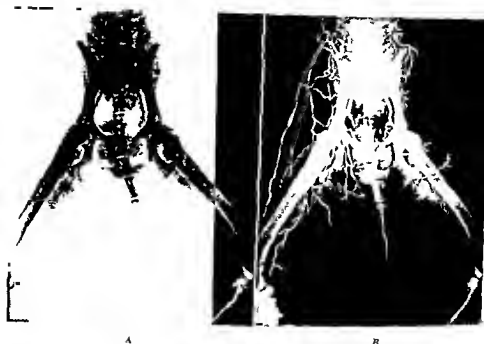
A Arteriogram seven days following excision of the trifurcation of the aorta and postoperative treatment with tetrathylammonium chloride. The deep circumflex iliac vessels are filled as are the internal iliac. B Retouched roentgenogram.
